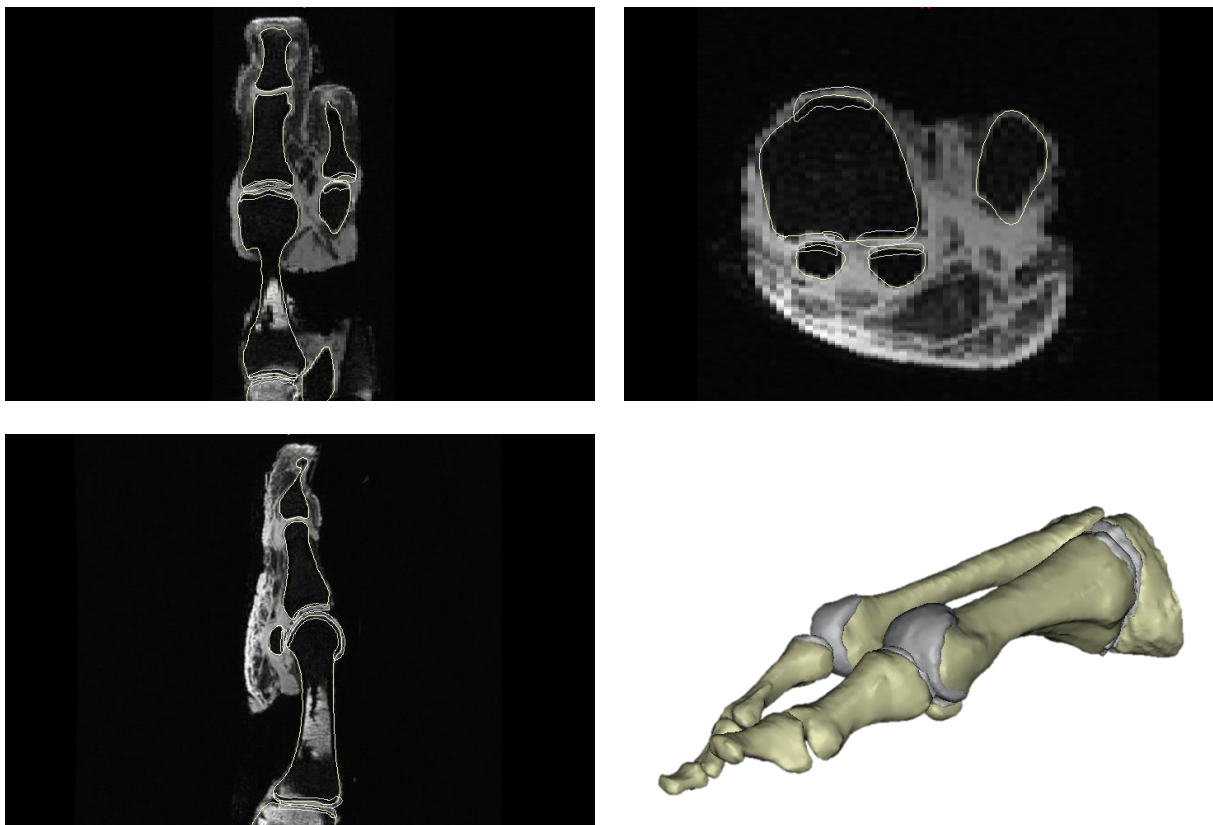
Image of the segmented geometries of the medial forefoot in Mimics. A 3T MRI-scan was used to image the soft tissues, enabling 3D reconstruction in preparation for FE model development.
